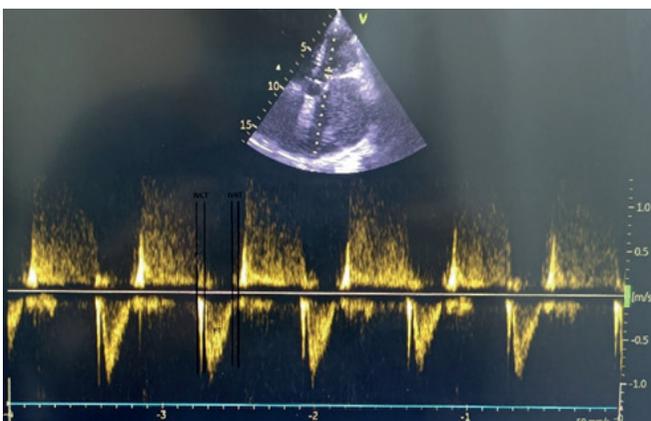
Assessment of myocardial performance index by pulse wave Doppler
